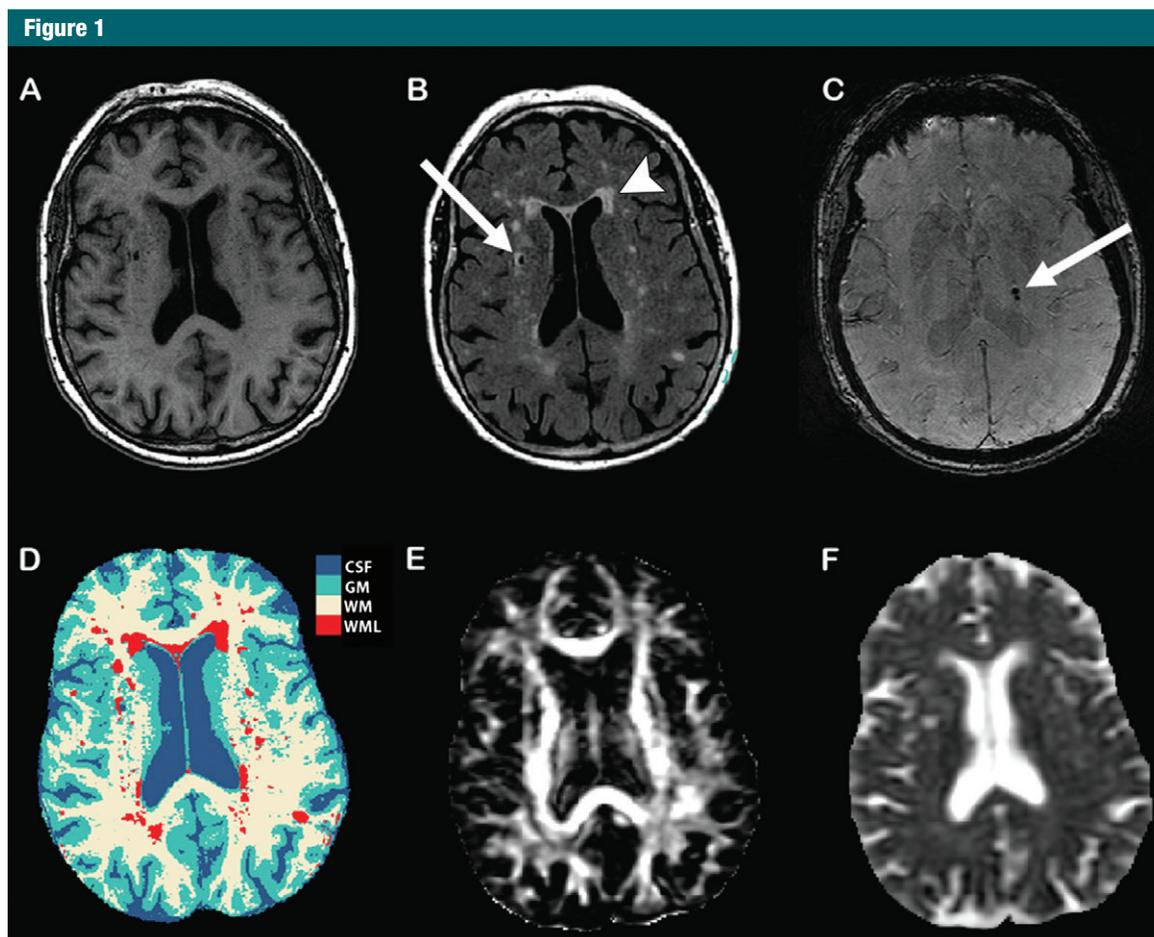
Structural and microstructural MR imaging markers of subclinical brain damage. The left side of each image corresponds to right side of the brain. *A*, T1-weighted image. *B*, Fluid-attenuated inversion recovery image shows WMLs (arrowhead) and lacunar infarct (arrow). *C*, Three-dimensional T2* gradient-echo MR image shows cerebral microbleeds (arrow). *D*, Tissue segmentation, with each tissue type represented by a different color. *CSF* = cerebral spinal fluid, *GM* = gray matter, *WM* = white matter. *E*, Diffusion-tensor imaging map of fractional anisotropy. *F*, Diffusion-tensor imaging map of mean diffusivity.
